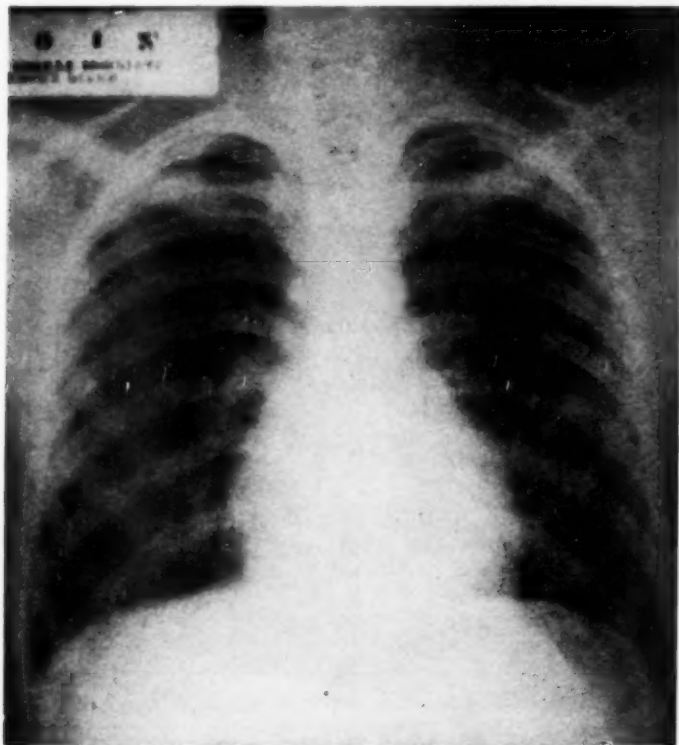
Roentgen-ray of chest taken in 1934 showing no pulmonary or cardiac lesions.
